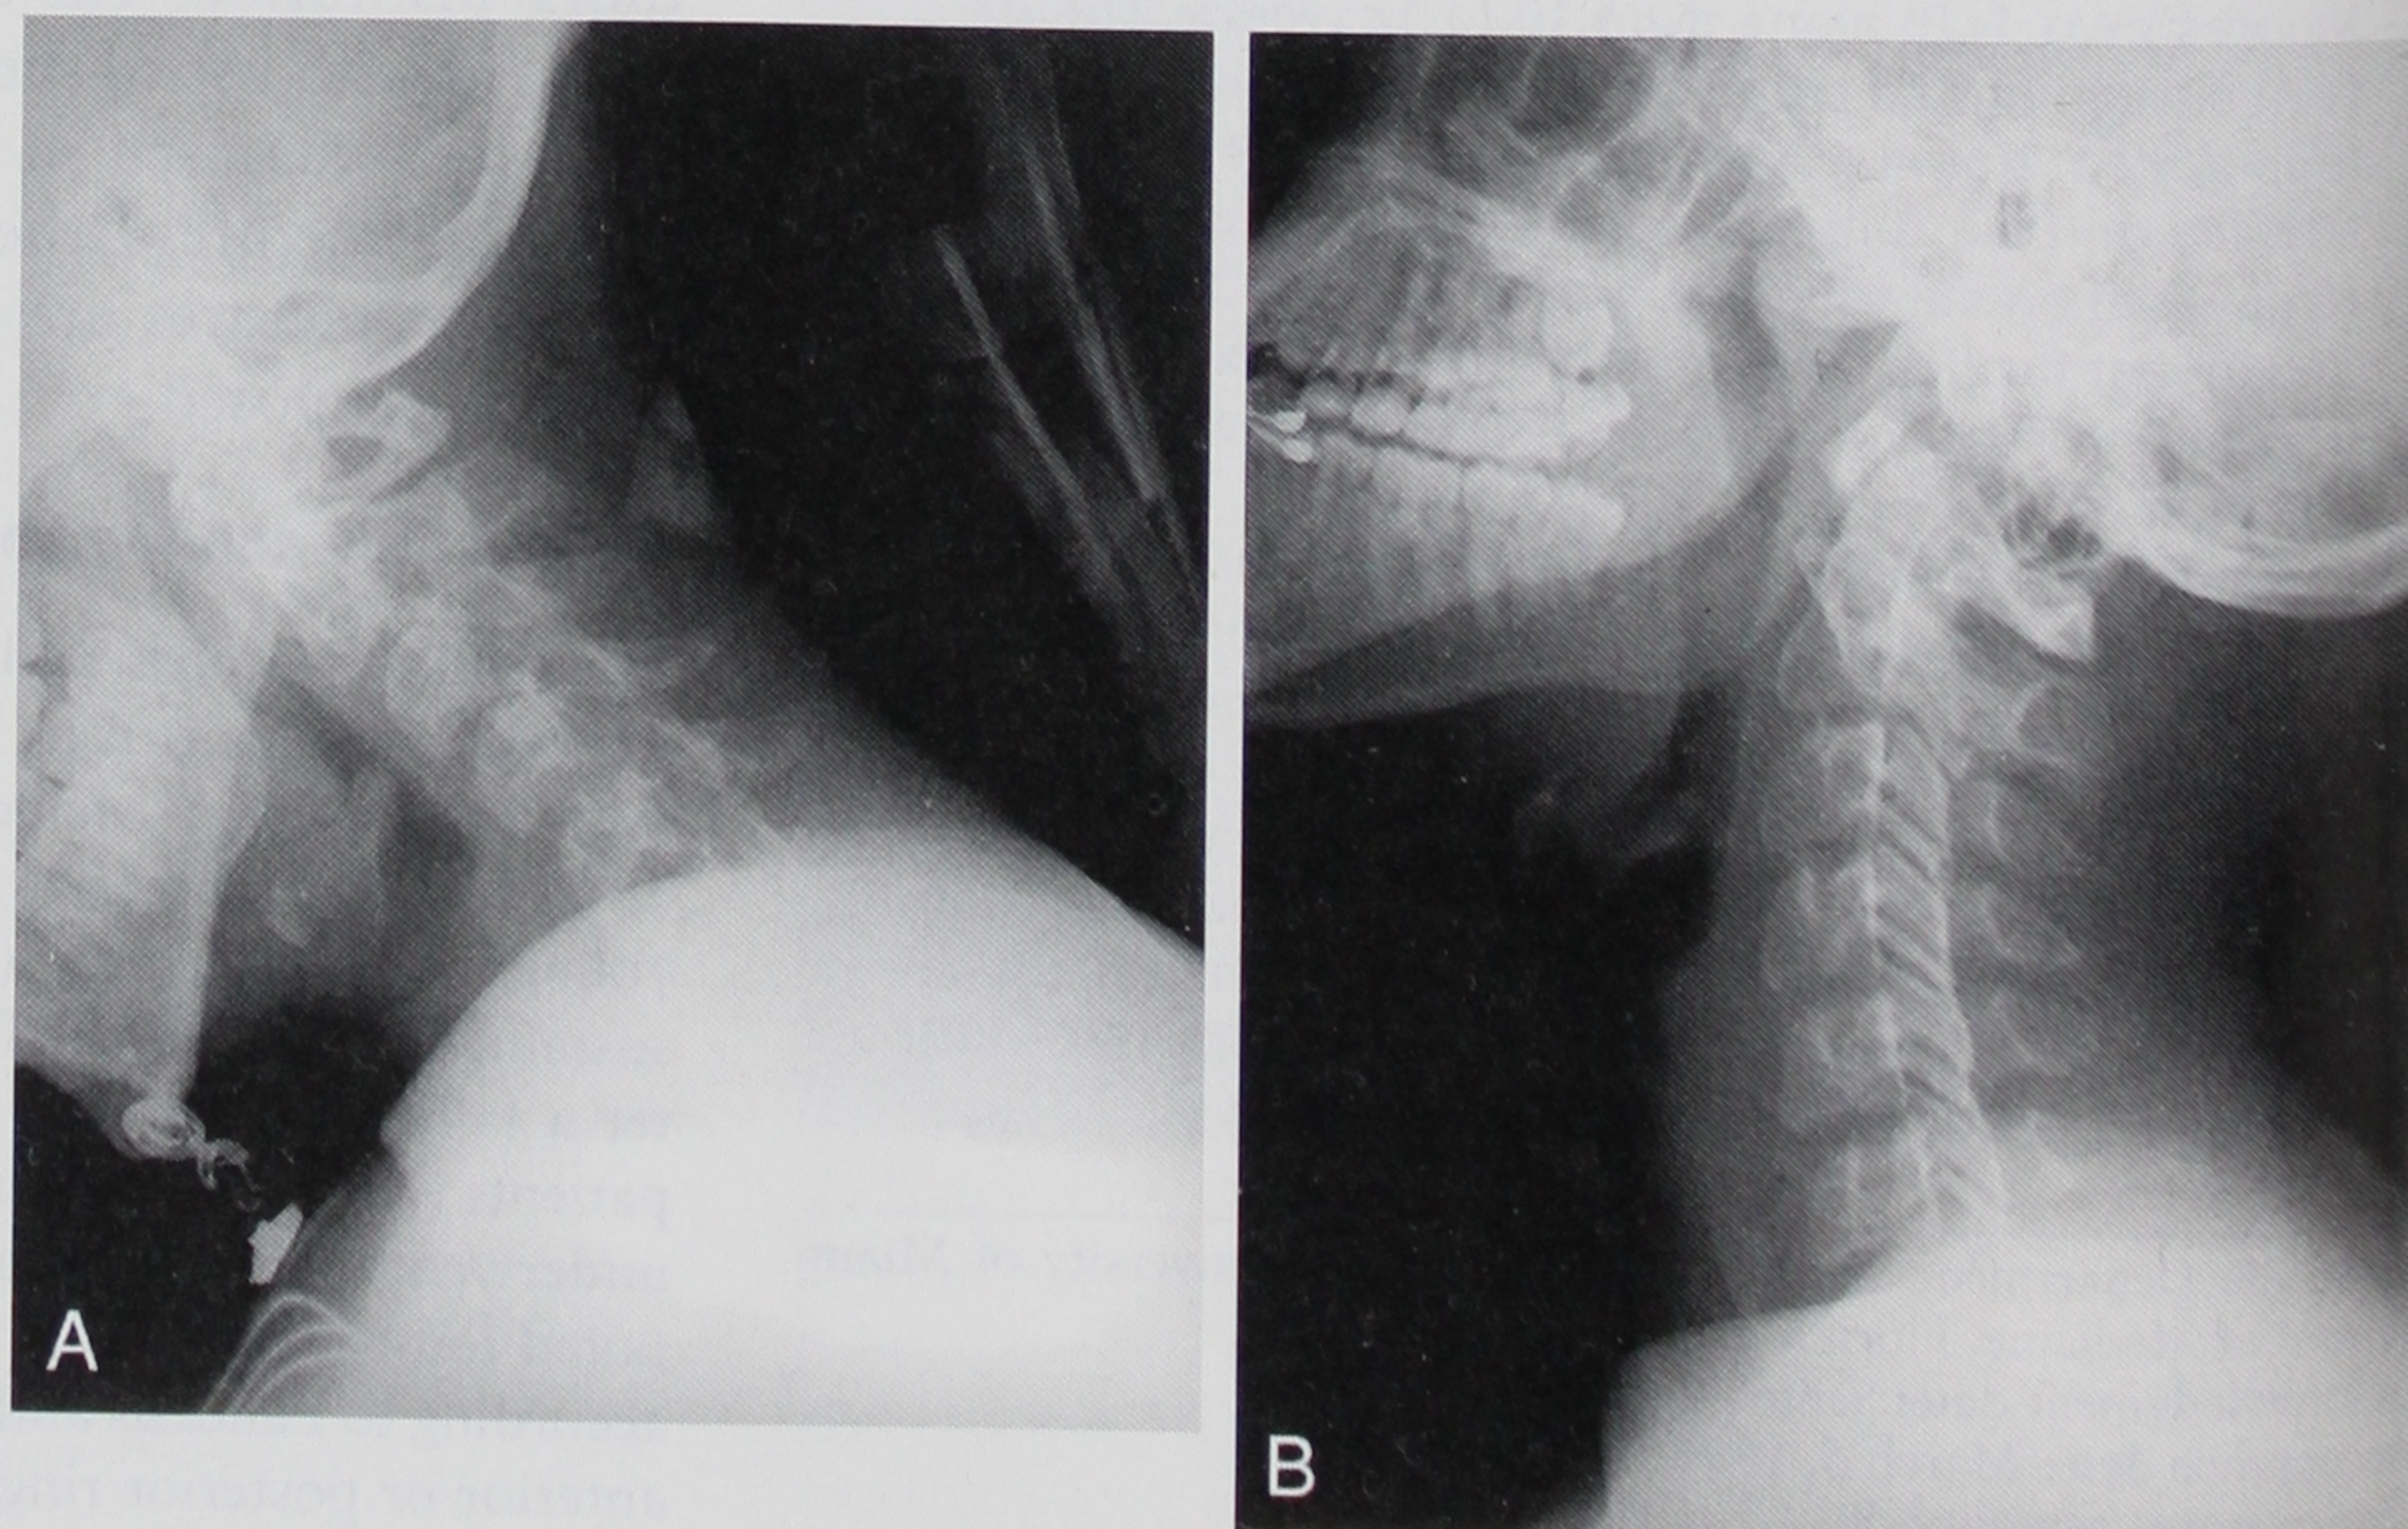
Flexion (A) and extension (B) lateral cervical spine radiographs of a patient with a Type I Jefferson fracture shows no segmental instability on follow-up.
